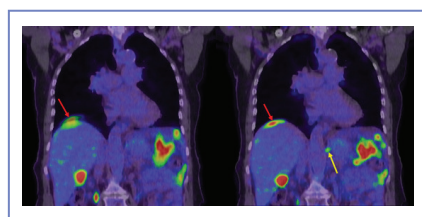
Free-breathing [¹⁸F]FDG acquisition (left) vs respiratory-gated acquisition (right). Red arrows show resolution of diaphragmatic motion artefact on the respiratory-gated image. Yellow arrow shows para-aortic [¹⁸F]FDG avid node only visualised on respiratory-gated acquisition.
